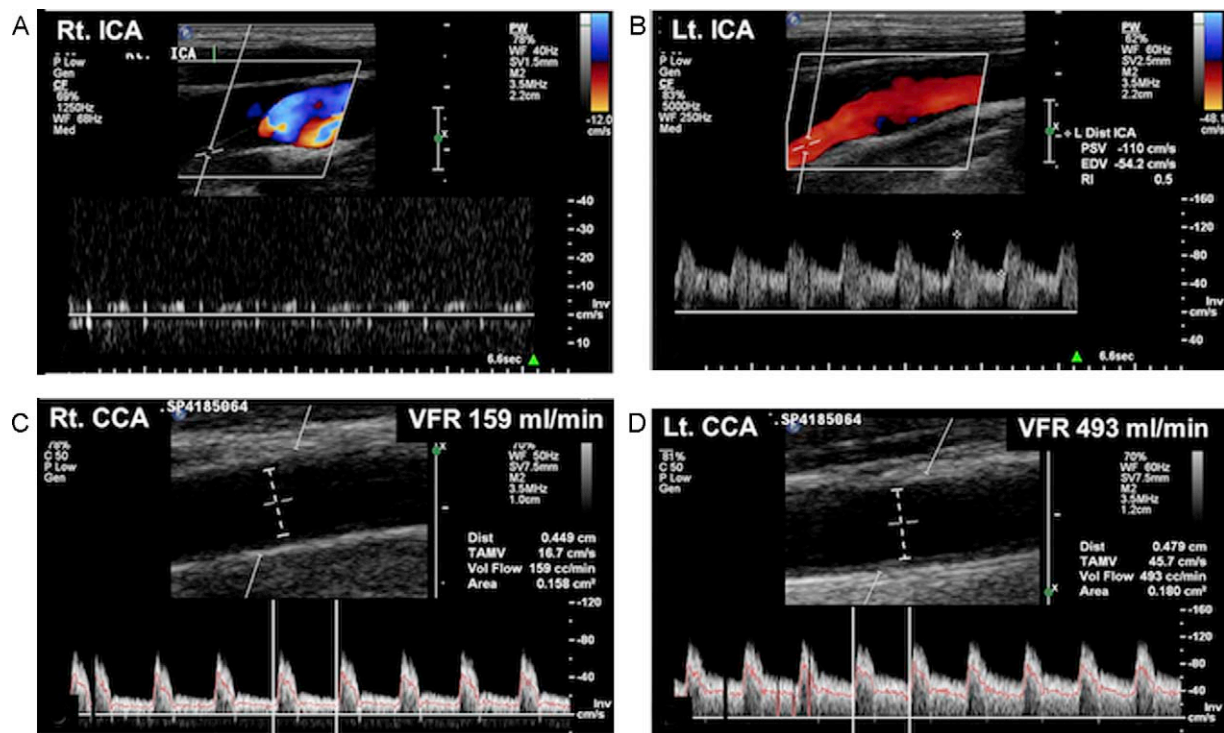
CCA VFR measured by Doppler method in a 46-year-old male with right ICA occlusion. Color flow imaging shows right ICA occlusion (A) and normal left ICA (B) with right CCA VFR of 159 ml/min (C), and left CCA VFR of 493 ml/min (D).
